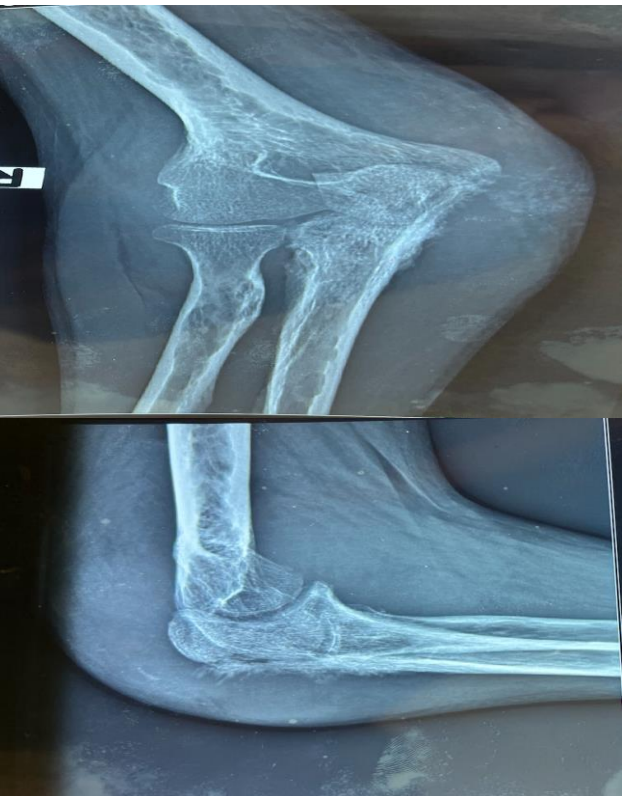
Early radiographs of the right elbow-AP and lateral views.
